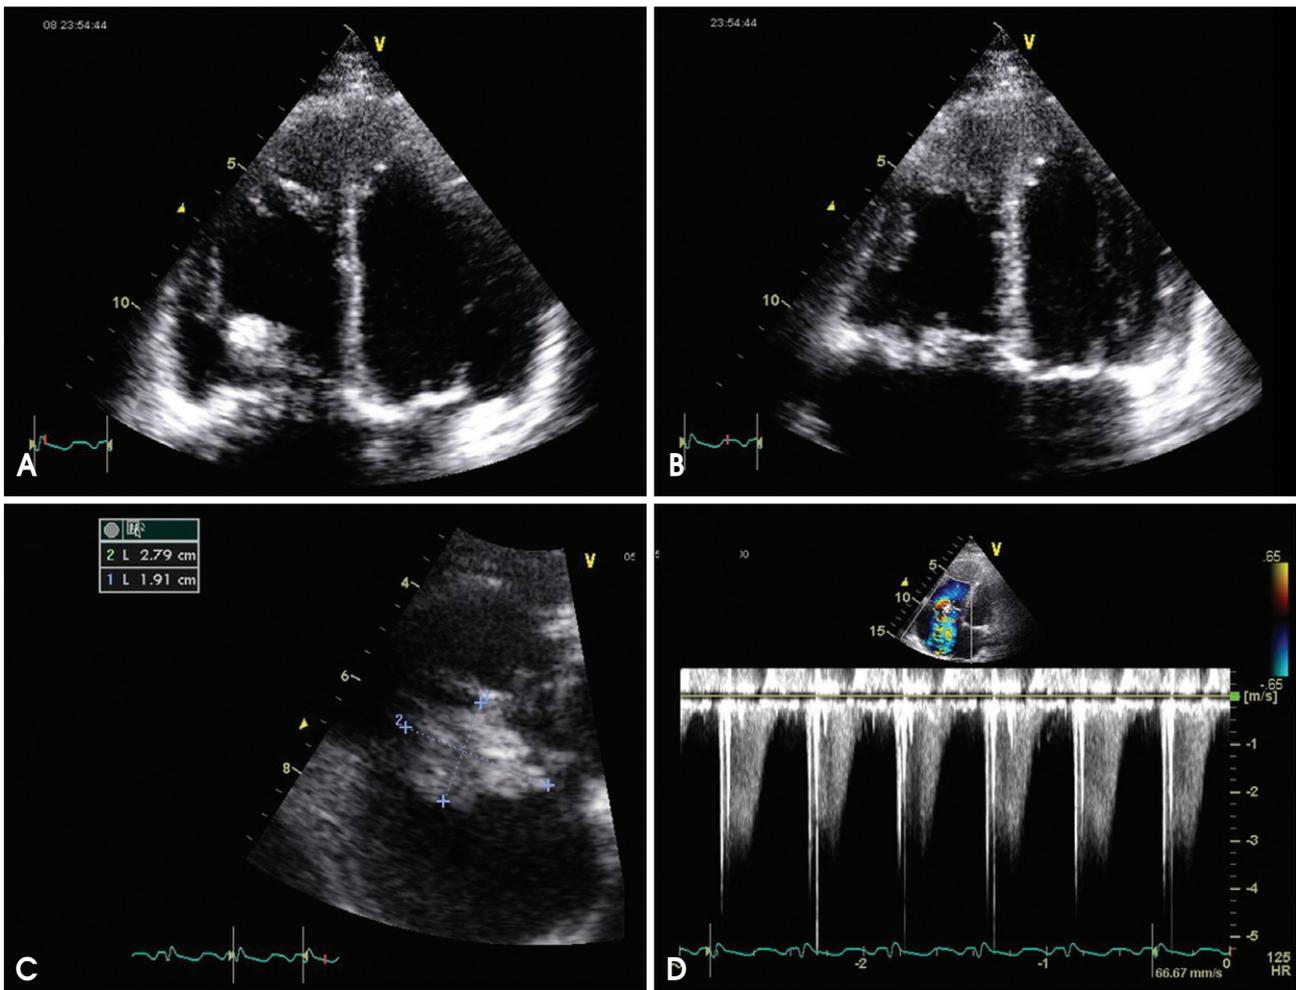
Echocardiographic examination at admission showed right ventricular dilatation and systolic dysfunction (A: End-diastole. B: End-systole). About 28 × 19 mm sized masses was noted on the TV (C). The measured maximal tricuspid regurgitation velocity was 3.9 m/s (estimated systolic pulmonary arterial pressure was 71 mmHg) suggesting severe resting pulmonary hypertension (D).
